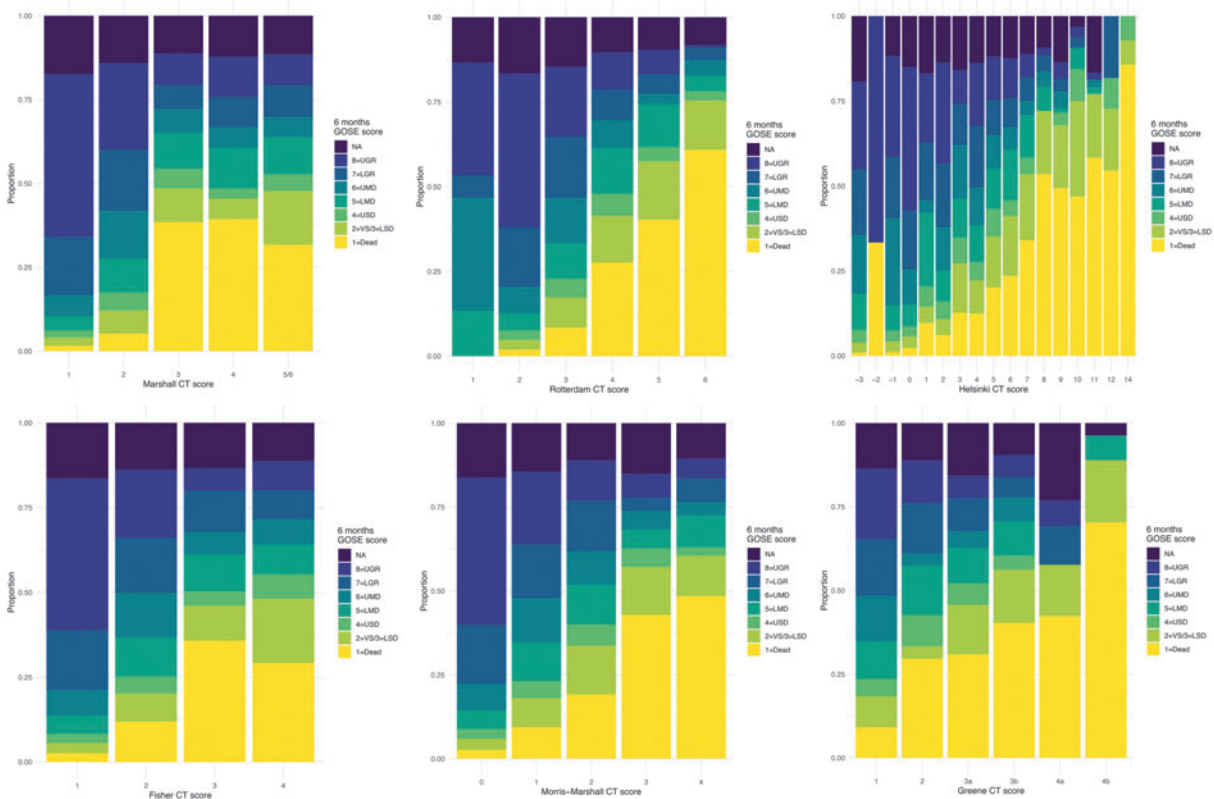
Six-month GOSE scores within the categories of traumatic brain injury (TBI) classification and grading systems in Collaborative European NeuroTrauma Effectiveness Research in TBI (CENTER-TBI) based on admission non-contrast CT findings. We can observe that the proportion of worse outcomes generally increases with the CT score category, for all six classifications. Some categories (e.g., Helsinki CT score -2) have very few observations (Supplementary Table S19). GOSE scores were assessed by in-person/telephonic interviews or postal questionnaires, and as such a clear distinction between GOSE 2 (VS) and GOSE 3 (LSD) was not always possible. As a result of this, these two categories were combined, giving a seven-point ordinal scale. CT, computed tomography; GOSE, Glasgow Outcome Scale-Extended; LGR, lower good recovery; LMD, lower moderate disability; LSD, lower severe disability; NA, not available; UGR, upper good recovery; UMD, upper moderate disability; USD, upper severe disability; VS, vegetative state.
